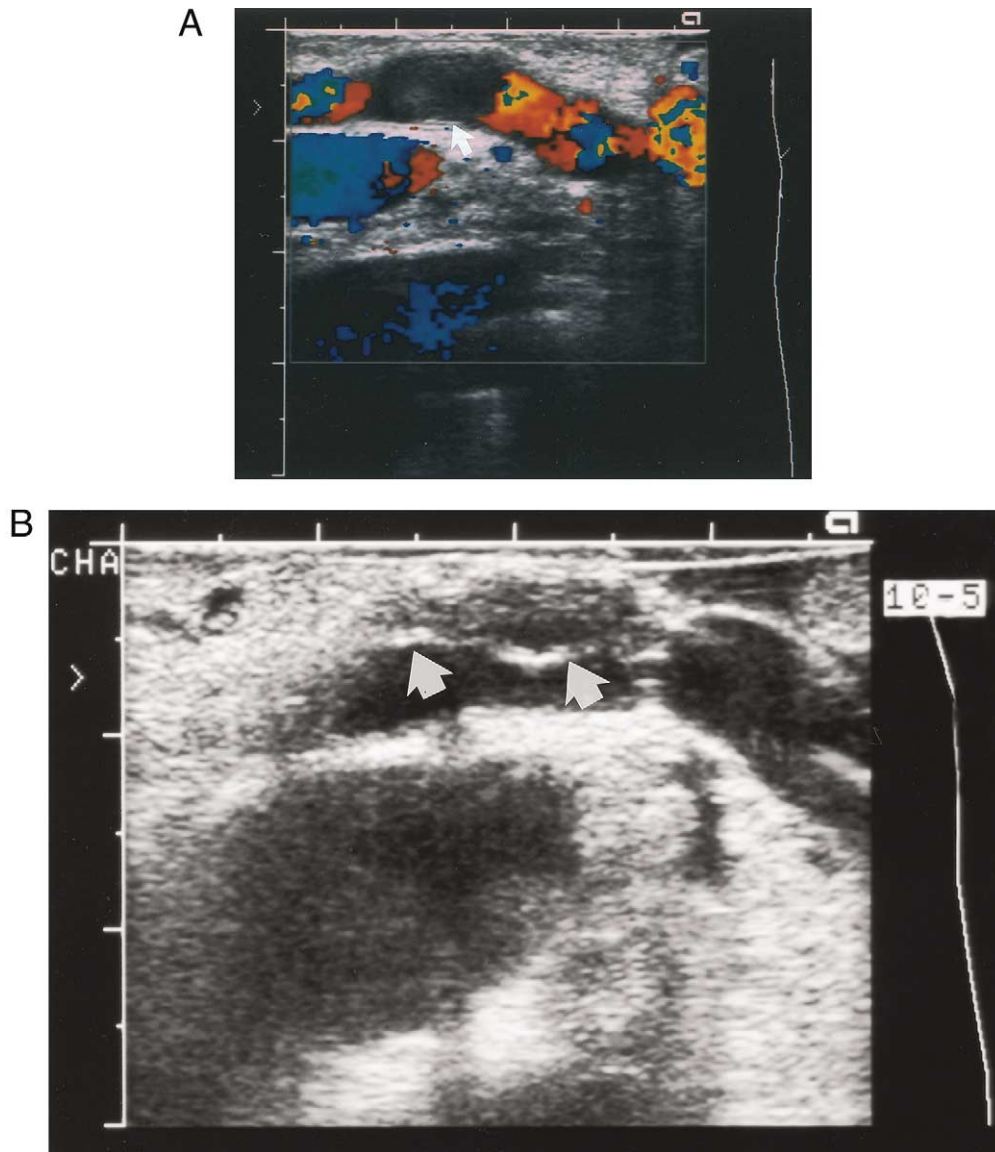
Color Doppler images reveal occlusive thrombus in the proximal common hepatic artery after aortoceliac-SMA bypass (A, *small arrow*). After thromboembolectomy, gray-scale sonogram demonstrates an intraluminal flap consistent with dissection (B, *large arrows*). Resection of the dissected intima and patch angioplasty resulted in normal repeat ultrasound.
